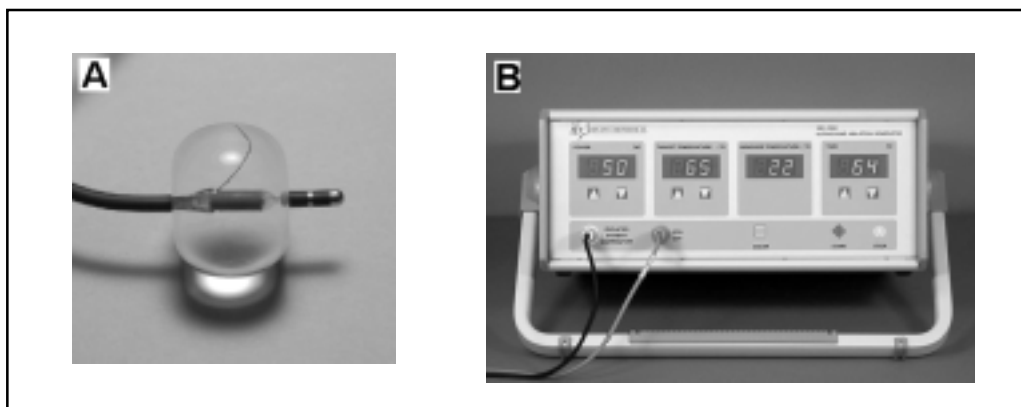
Configuration of a ultrasound balloon catheter (A) and an ultrasound ablation generator (B). They were manufactured by IBI Co. Ltd.
